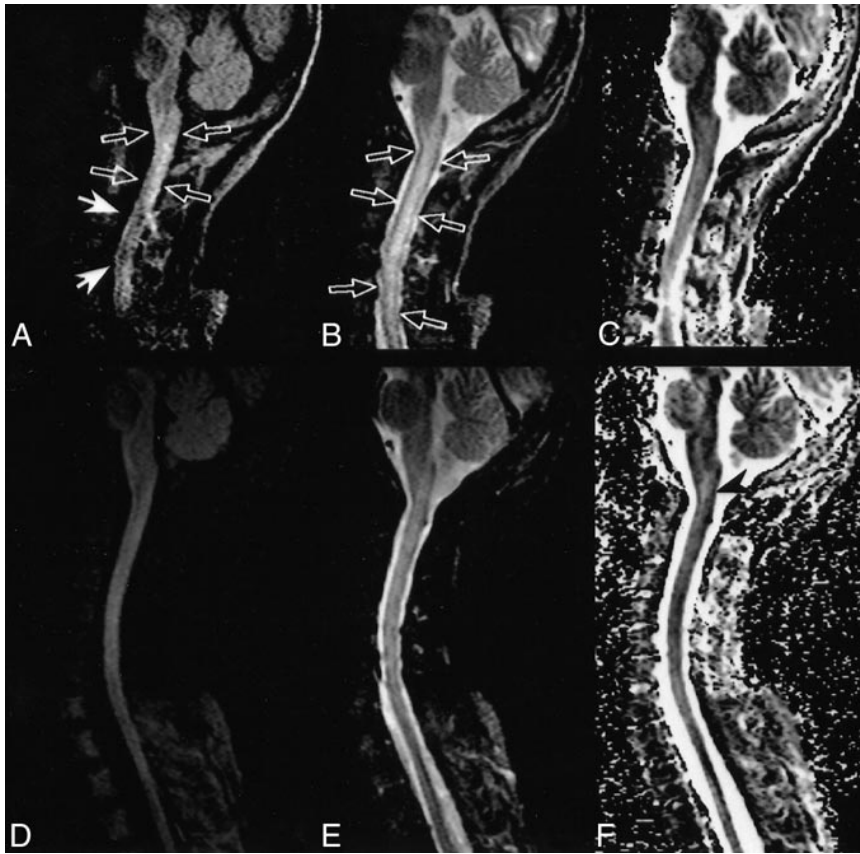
Only mild hyperintensity was seen on diffusion-weighted MR images of a patient with myelitis.
